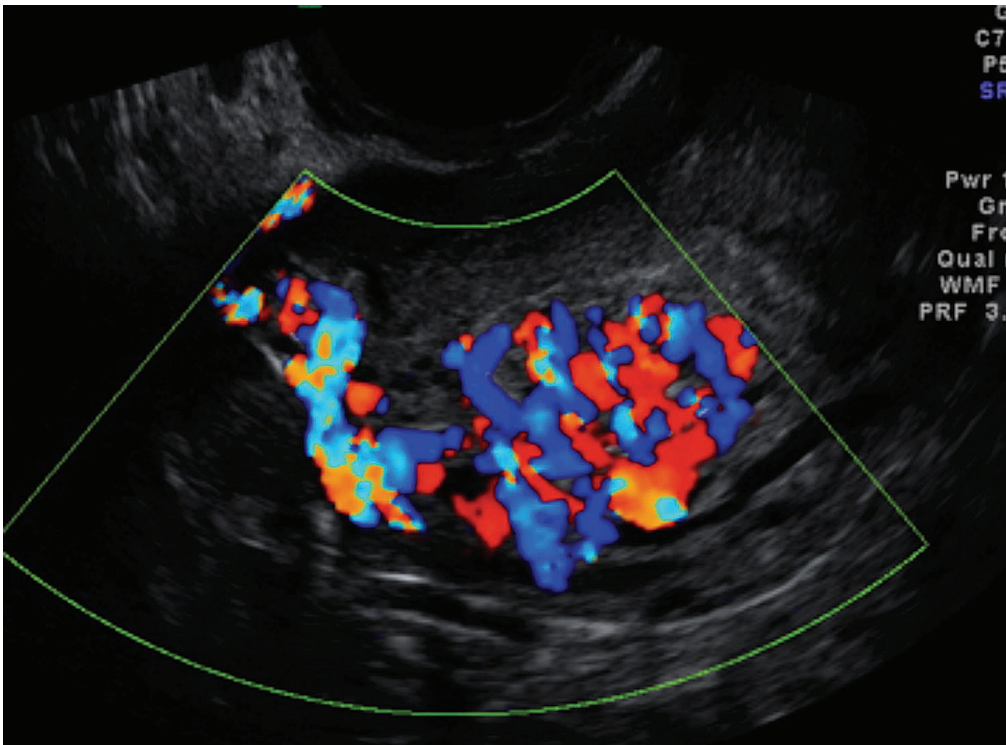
Colour Doppler image demonstrating turbulent flow creating a mosaic pattern.
